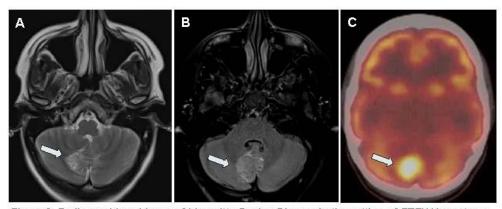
Radiographic evidence of Lhermitte-Duclos Disease in the setting of *PTEN* Hamartoma Tumor Syndrome. Axial cross-sections of T2-weighted MRI of the brain demonstrating a hyperintense mass centered in the inferior vermis and right cerebellar hemisphere (white arrows) consistent with a dysplastic cerebellar gangliocytoma (Lhermitte-Duclos Disease) (A) with perilesional vasogenic edema as shown on T2-weighted Fluid Attenuated Inversion Recovery (FLAIR) imaging (B). Axial cross-section of FDG PET/CT confirms a highly FDG-avid right cerebellar mass.
